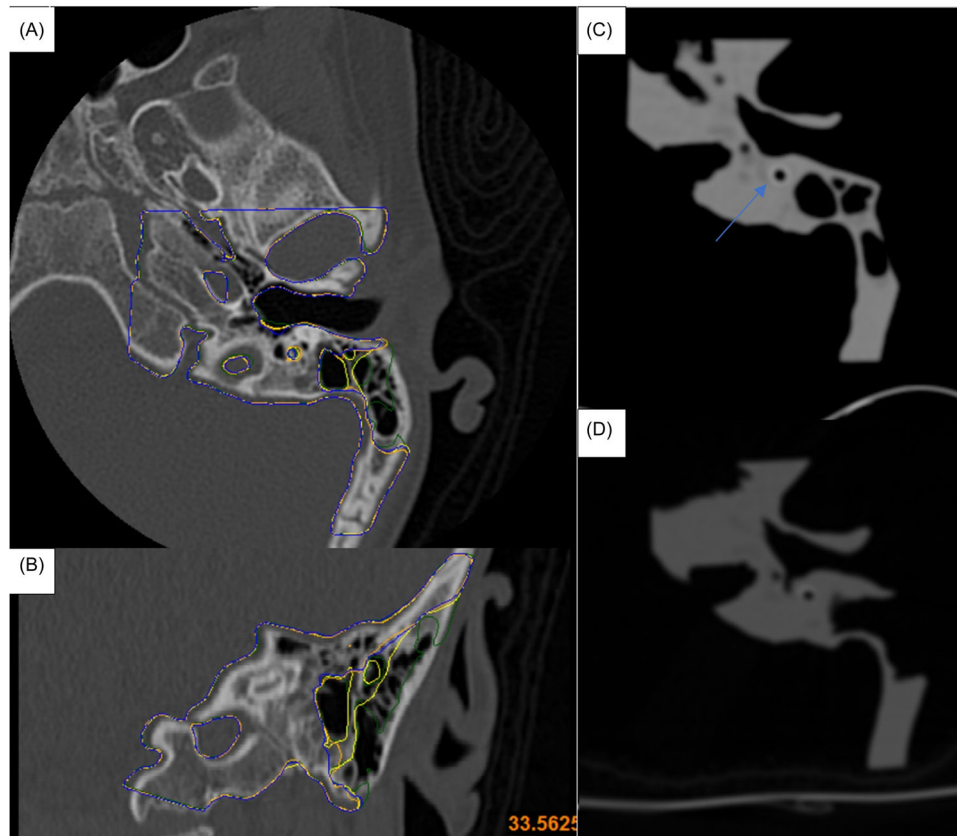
Segmentation lines from the copy models overlaid onto the patient CT Scan. Segmentation lines from the copy models are overlaid onto the original axial (A) and coronal (B) patient CT scan. Green is step 1, yellow is step 2, orange is step 3, and blue is step 4. (C) CT scan of the drilled step 1 model. While the photoacrylic material is a uniform color on CT, the topography and hollow cavities are preserved. Note the brighter density of the facial nerve canal due to paint (arrow). (D) Axial CT scan of the drilled step 4 model. CT, computed tomography.
